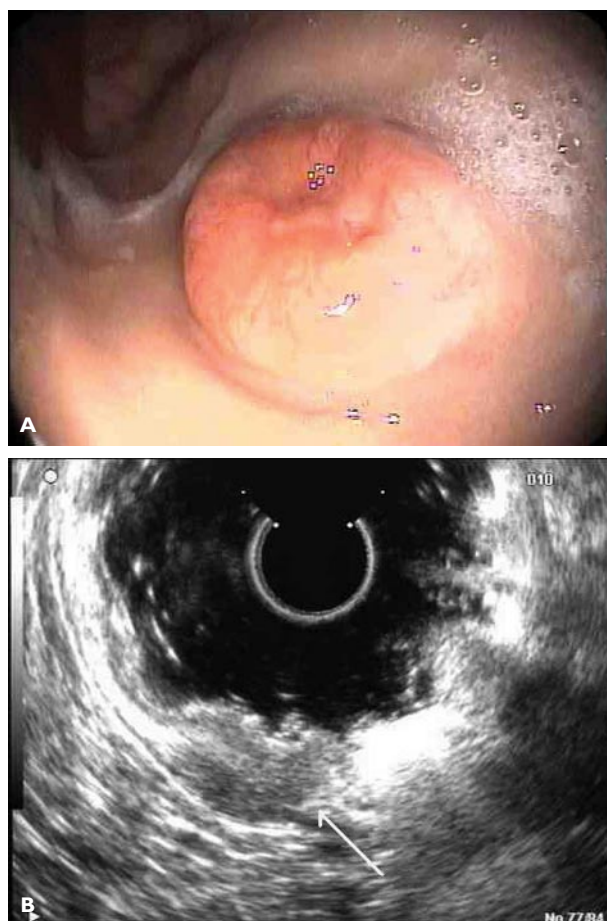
(A) Gastric neuroendocrine tumor seen in the gastric fundus on endoscopy and (B) endoscopic ultrasound of the same lesion (arrow). Note that the lesion invades all layers of the gastric wall but does not erode through the adventitia.
